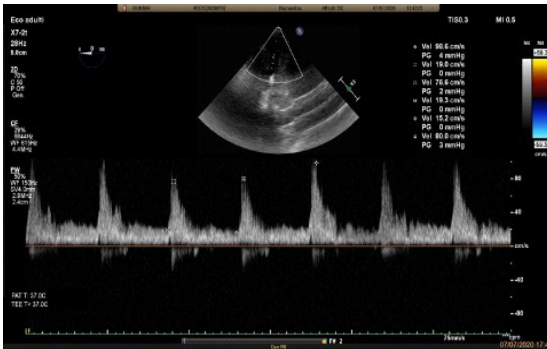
Trans-esophageal pulsed wave Doppler evaluation of the celiac trunk at the end of the laparoscopic section of the arcuate ligament. Notice the variation of the PSV with the mechanical respiratory cycle.
